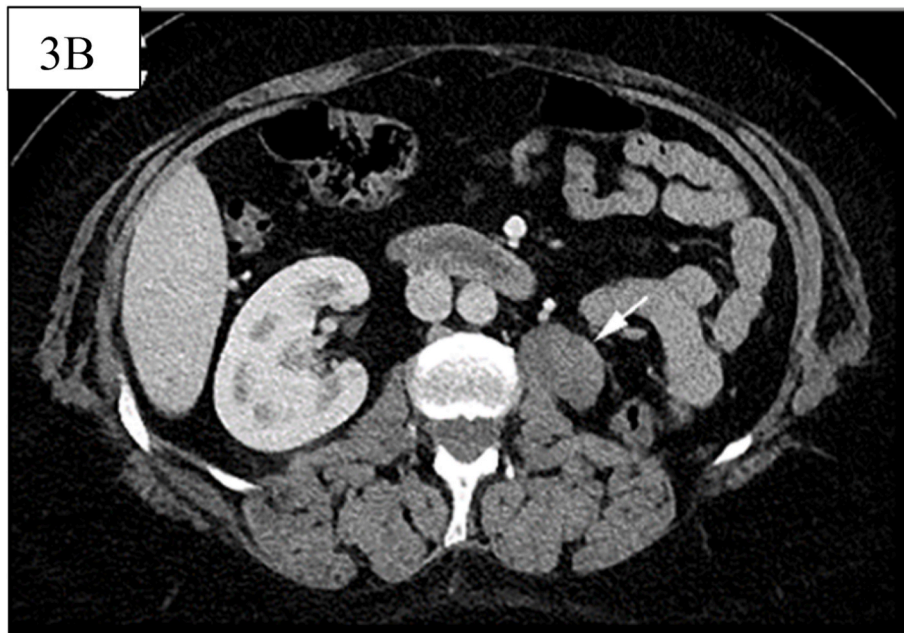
CT from 2018 with intravenous contrast. Soft tissue process in the left kidney's bed (white arrow).
